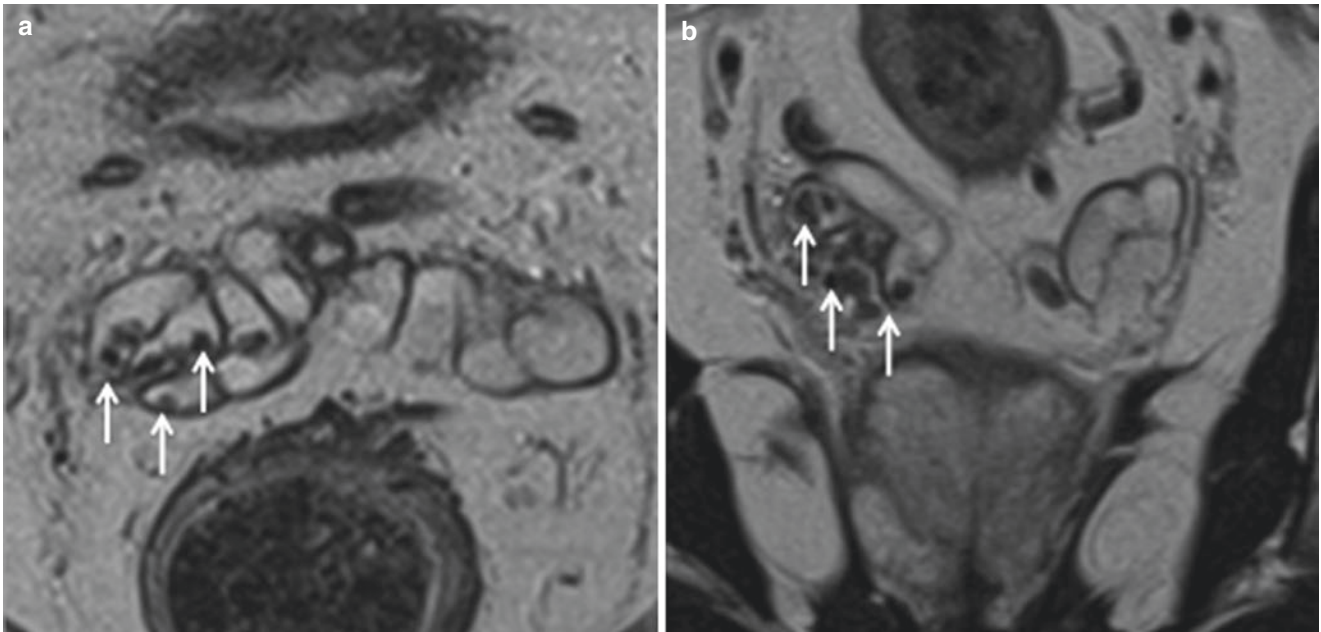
Calculi in a 30-year-old man with hematospermia. Axial (a) and coronal (b) T2-weighted MR image shows calculi in the right SV (arrows)
